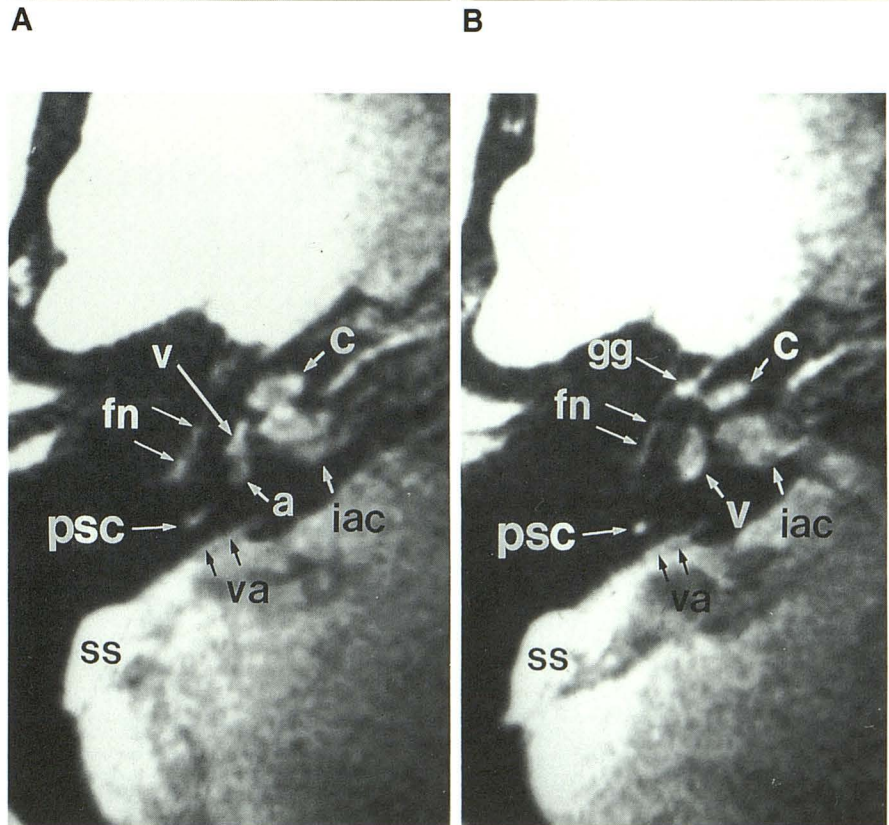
Axial 3DFT MR images. See key for abbreviations.
